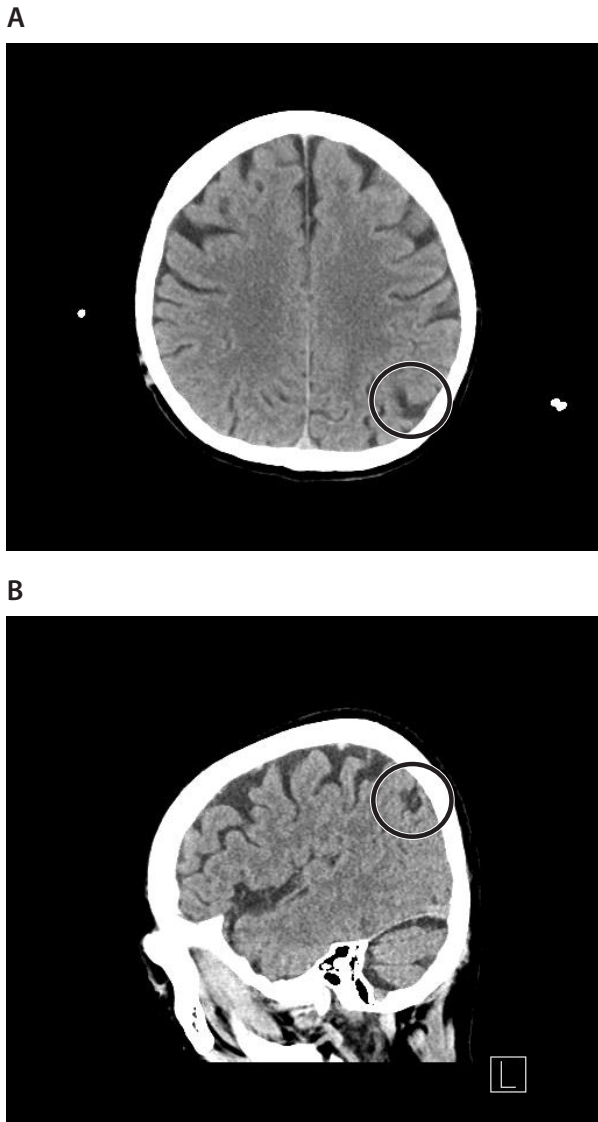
Head Computed Tomography Showing a Low Density Area (Circle) Suggestive of Old Infarction at the Border of the Left Parietal Lobe and Occipital Lobe
